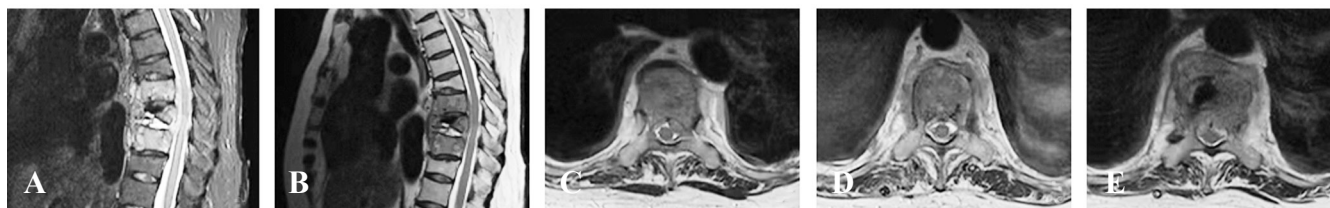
Typical case involves a 76-year-old female diagnosed of spinal tuberculosis who was misdiagnosed as having an osteoporotic compression fracture after undergoing percutaneous vertebroplasty. The patient's initial American Spinal Cord Injury Association (ASIA) grade was B before surgery. Following the uniportal endoscopic decompression and debridement via a transforaminal approach, the patient's ASIA grade improved to C. At the 1-year follow-up, the patient achieved an ASIA grade of E. (A–E) Preoperative X-ray, computed tomography (CT), and magnetic resonance imaging radiographic examination revealed bone destruction of the T9–10 vertebrae and formation of a ventral epidural abscess that compressed the spinal cord. (F–G) Marked lines for the target intervertebral disc were obtained by C-arm fluoroscopy. (H–J) Endoscopic working channel establishment. (K–M) Soft tissue cleaning and foraminoplasty with a trephine and high-speed grinding drill. (N–P) Intraspinal exploration of the anatomical relationship between abscess and dural sac. (Q–S) Endoscopic decompression and debridement by grasping ventral epidural abscess and suspected infected tissue. (T) Final exploration after ventral dural sac decompression. (U–W) A negative pressure drainage tube was placed into the target disc space with confirmation of fluoroscopy. (X, Y) Postoperative CT revealed foraminoplasty of the T9–10 vertebrae (red arrow and circle). IAP, inferior articular process. SAP, superior articular process.
